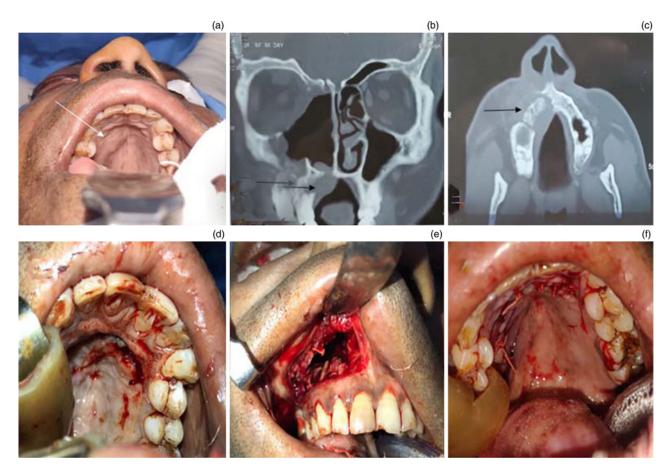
Case 1. (a) Pre-operative image. White arrow indicating palatal bulge. (b) Coronal plane contrast-enhanced computed tomography image of the nose, paranasal sinuses and orbit. Black arrow indicates right hard palate erosion. (c) Axial plane contrast-enhanced computed tomography image of the nose, paranasal sinuses and orbit. Black arrow indicates right hard palate erosion. (d) Intra-operative image showing palatal incision. (e) Intra-operative image showing gingivolabial flap. (e) Intra-operative image after closure.
